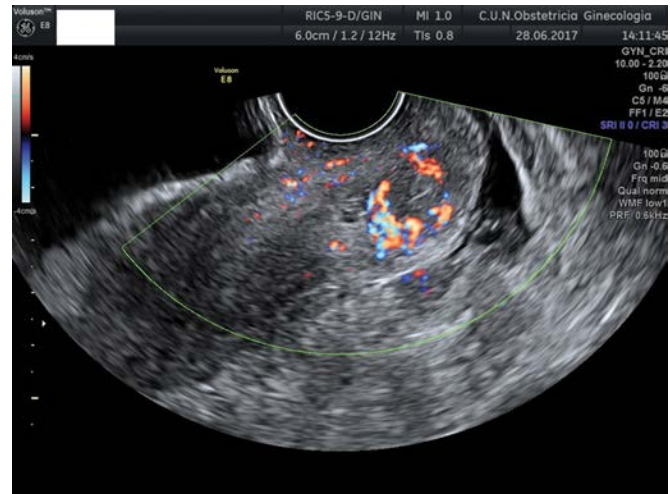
Transvaginal ultrasound showing a highly vascularized lesion in the cervix. This woman had a past history of complete hydatiform mole 3 years before. Beta-hCG monitoring was normal until this scan was performed. However, at this time β -hCG was 204 IU/mL. The patient underwent hysterectomy, and permanent frozen section demonstrated a choriocarcinoma.
